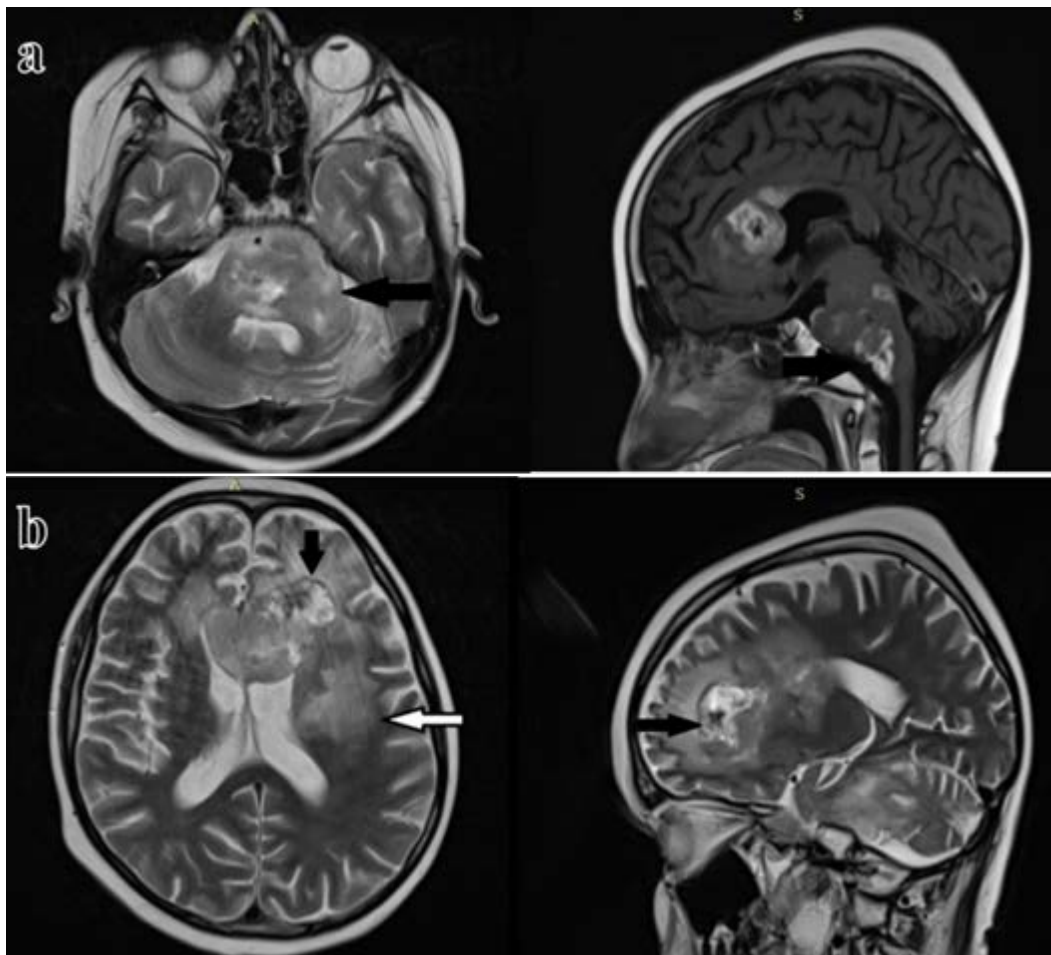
Brain magnetic resonance imaging after 8 cycles of adjuvant temozolomide.
